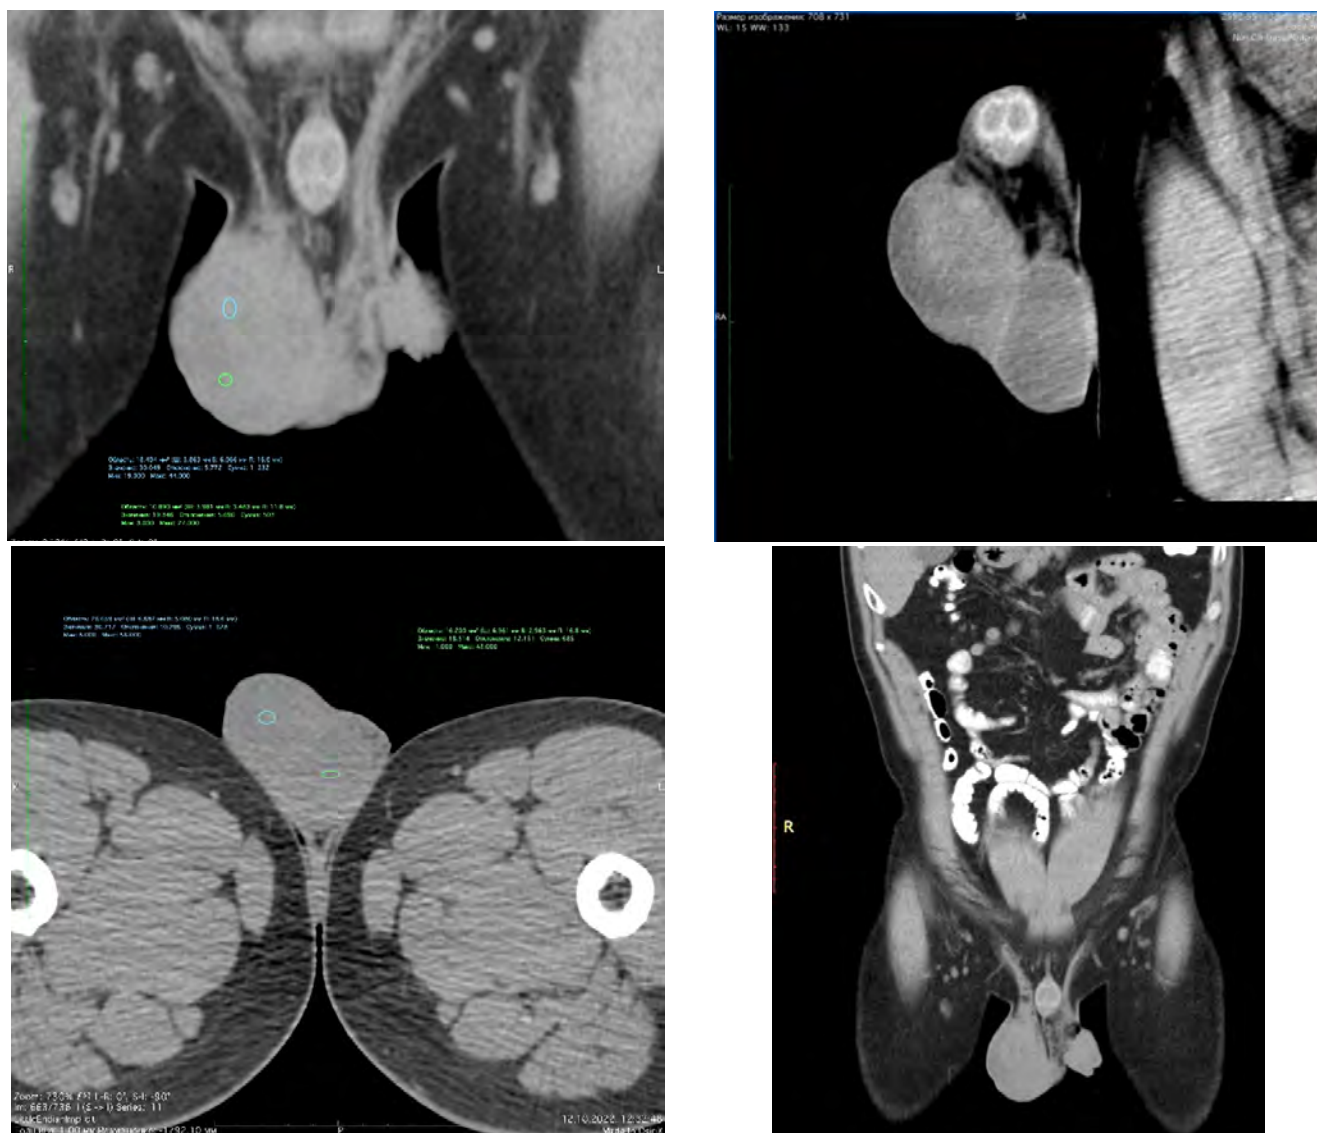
Patient T. Primary testicular diffuse large B-cell lymphoma of the testis. Contrast-enhanced computed tomography: enlarged right testis (56 × 43 mm)
